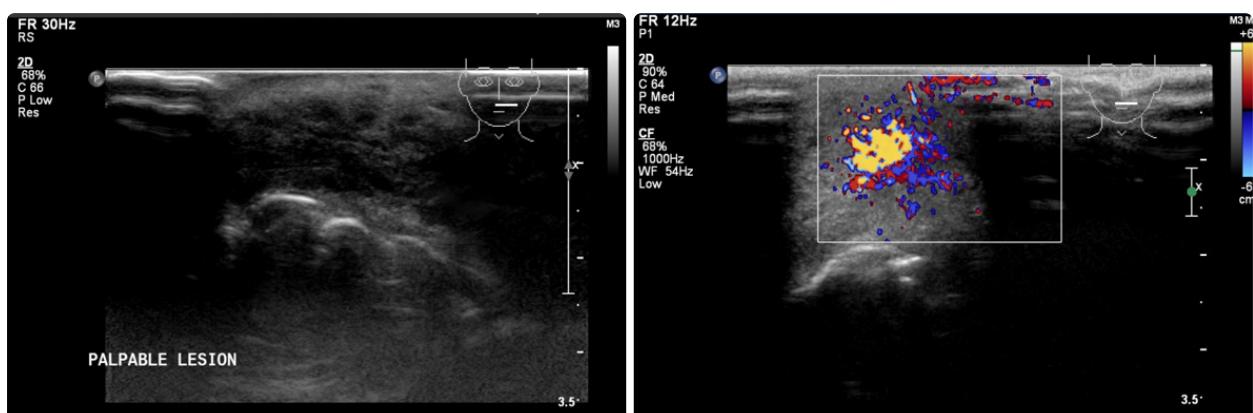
Ultrasound of upper lip and left cheek revealed an ill-defined infiltrative lesion in subcutaneous tissue with moderate internal vascularity.
